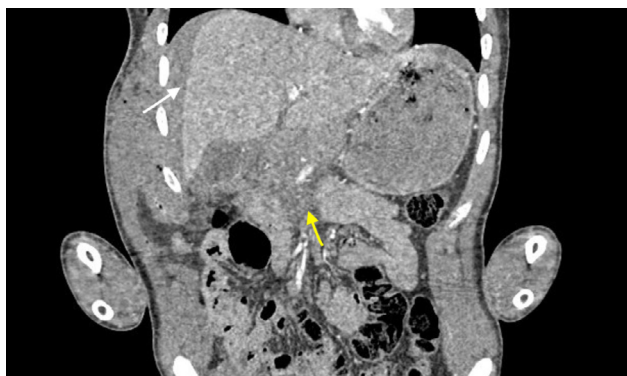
Preoperative coronal computed tomography (CT) image. Yellow arrow: severe pancreatic injury; white arrow: free intraperitoneal fluid.
